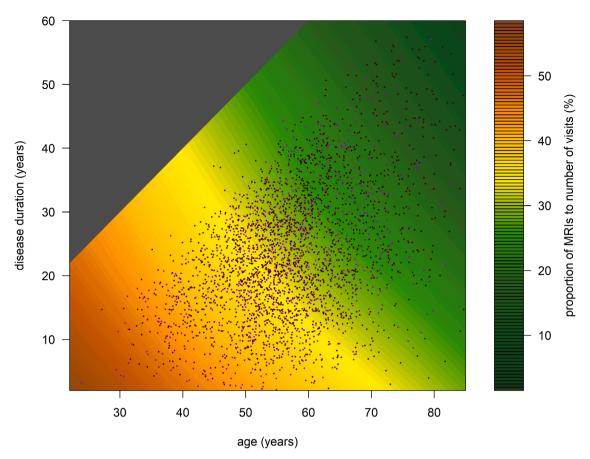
Proportions of updated MRIs depending on age and disease duration. For the last recorded visit per SPMS patient, the orange and yellow areas indicate that more than 30% of visits were associated with an updated MRI status, while the green areas indicate rates of less than 30%. The light purple points indicate a visit with updated MRI information, while the dark brown points indicate visits without updated MRI information. MRI, magnetic resonance imaging.
